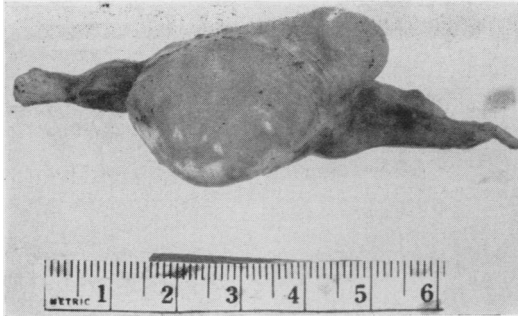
Tumor removed from patient whose roentgenogram is seen in Figure 6. Note part of the intercostal nerve entering and leaving the body of the neoplasm.
